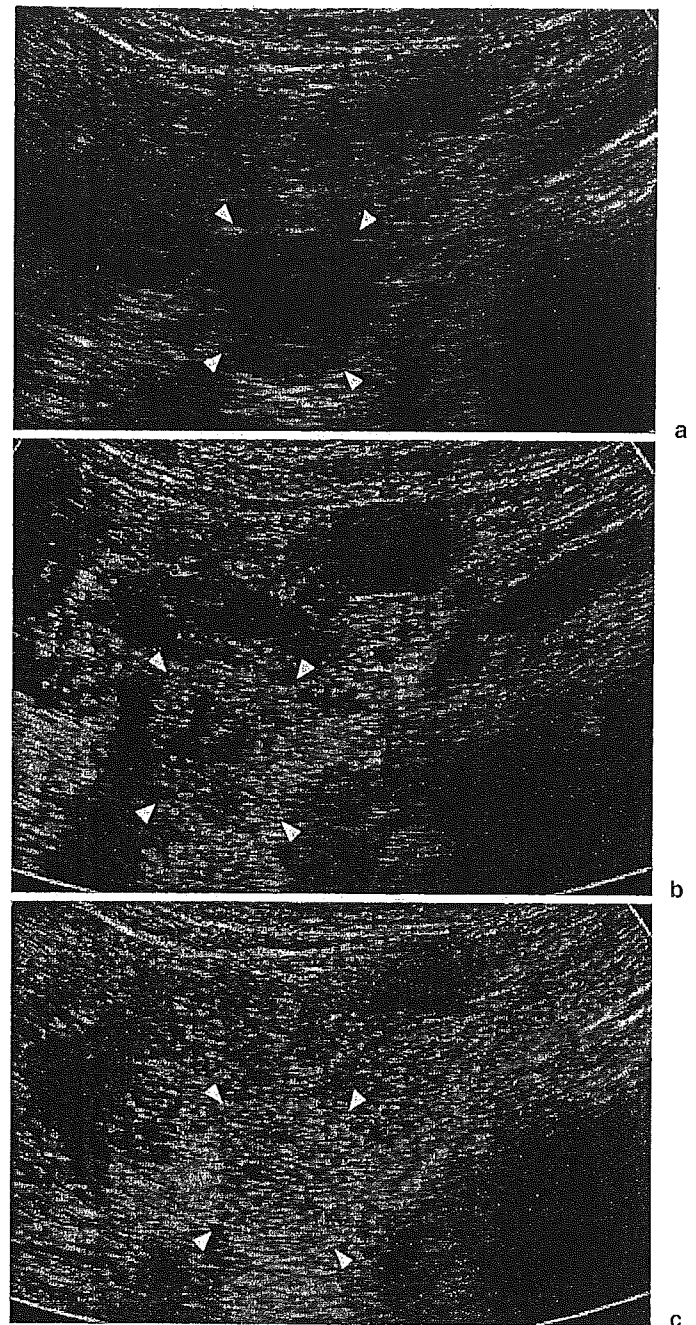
A case of moderately differentiated adenocarcinoma of the pancreatic head. B-mode ultrasound (US) showed a hypoechoic tumor (a), and contrast-enhanced (CE)-US revealed a hypovascular pattern and punctate flow signals throughout the lesion both on the vascular image (b) and the perfusion image (c). *Arrowheads* in a show the outline of the tumor
